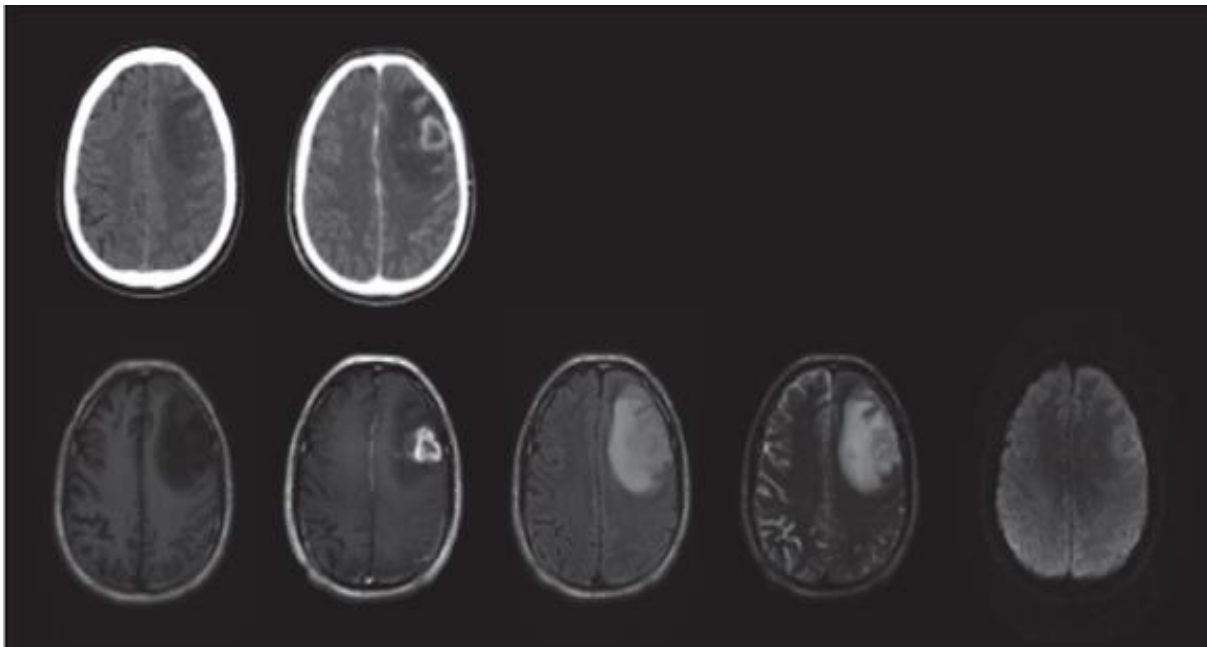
Glioblastoma Multiforme. Top row: CT images, without CE (left), and with CE (right).Bottom row: MR images. From left to right: T1-weighted, Contrast-Enhanced T1-weighted, FLAIR, and T2-weighted, diffusion-weighted.
